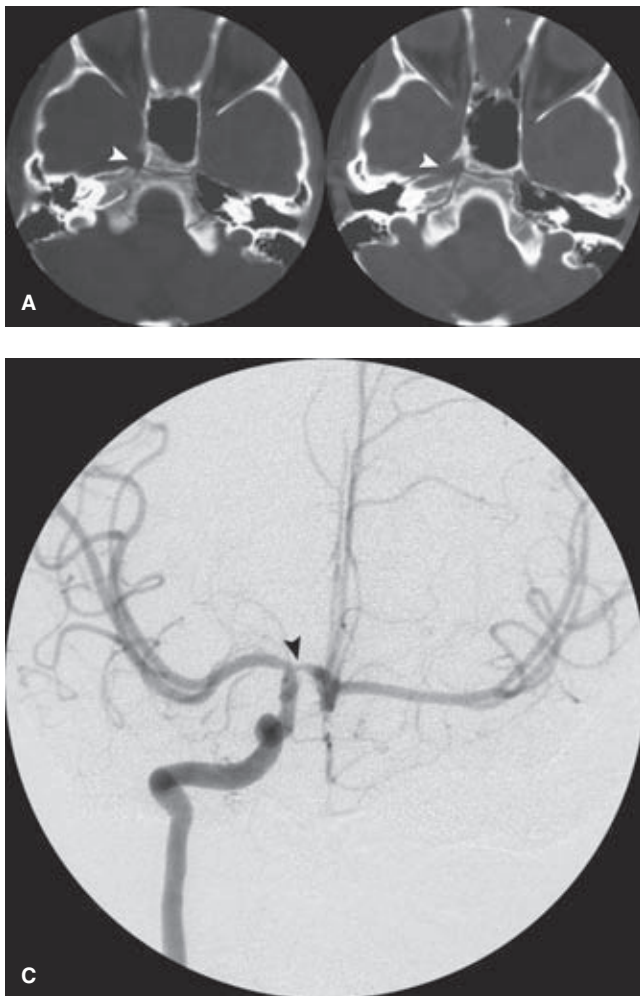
(A–C) Agnesis of the left internal carotid artery. A 9-year-old child with intermittent ischemic symptoms in the left hemisphere with demonstration of agnesis of the left internal carotid artery. The CT scan bone windows of the skull base demonstrate a normal carotid bony canal (*arrowheads*) on the right side, but no such corresponding structures on the left. The time-of-flight magnetic resonance angiography (TOF MRA) (B) confirms the normal-appearing right internal carotid artery (*white arrowheads* in B), but no left internal carotid artery. Subsequent cerebral angiography demonstrated no evidence of an internal carotid artery on the left side, representing presumed agnesis or early pre/perinatal occlusion. The right internal carotid artery AP view (C) shows prompt cross filling via the anterior communicating artery to the left hemisphere, but unfortunately, there is evidence of early stenosis or narrowing of the right A1 segment (*arrowhead* in C), which was thought to be the explanation of her development of new symptoms.
